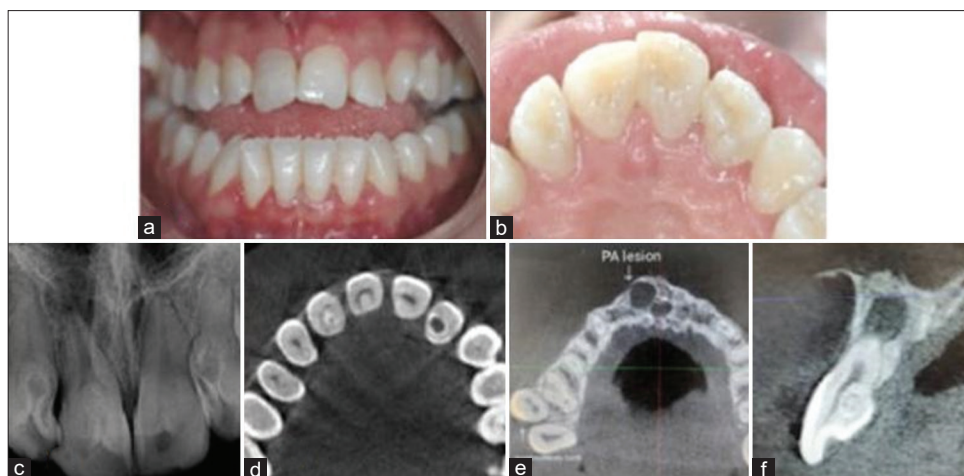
(a) Clinical view of dentition showing anterior open bite and Class III malocclusion; (b) intraoral photograph showing dens invaginatus in the permanent maxillary incisors; (c) intraoral radiograph showing dens invaginatus in the permanent maxillary incisors and periapical radiolucency in relation to the tooth #11; (d) axial view of cone-beam computed tomography; (e) extension of periapical radiolucency; (f) cross-sectional view of cone-beam computed tomography tooth #11
